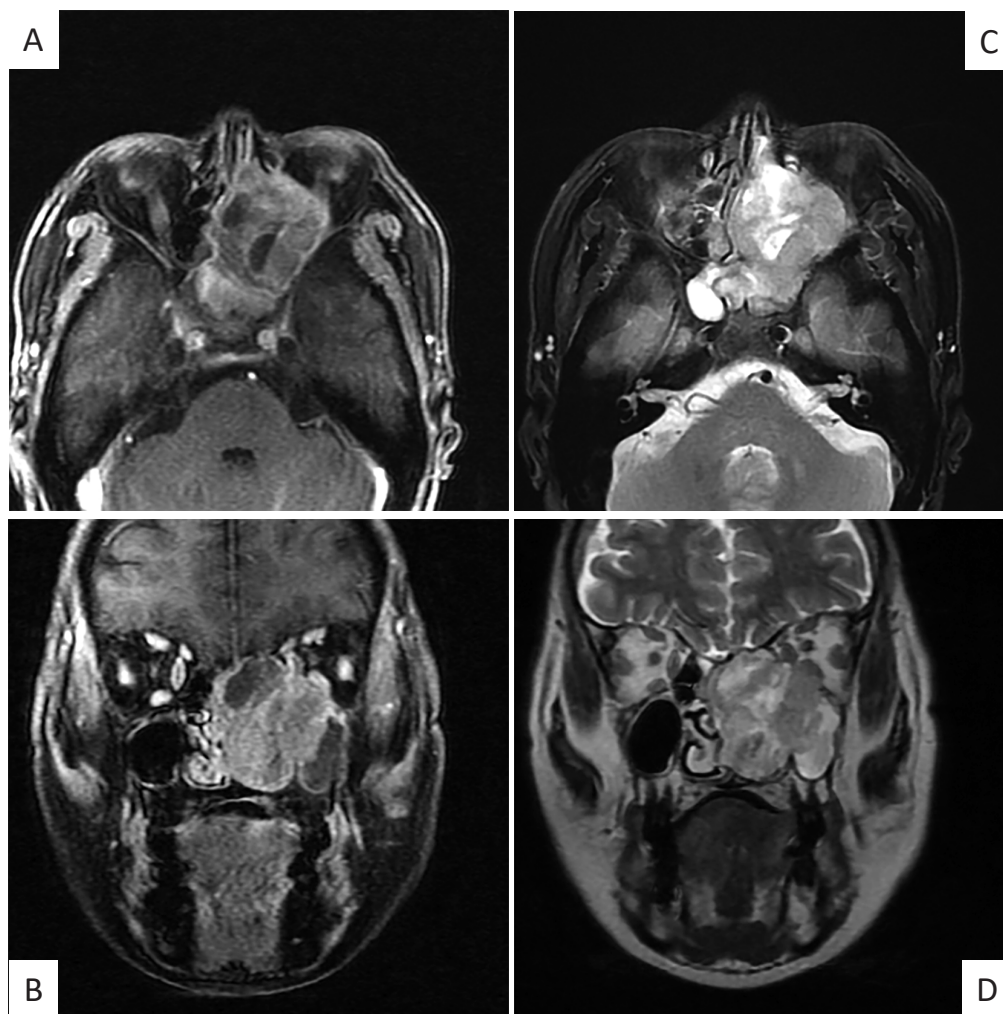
Magnetic resonance imaging (MRI) at admission. Fat suppressed contrast-enhanced T1-weighted (A ; axial, B ; coronal), and T2-weighted (C ; axial, D ; coronal) images showing a heterogenous contrast-enhanced mass occupying the left nasal cavity and infiltrating the bones of the paranasal sinus.
